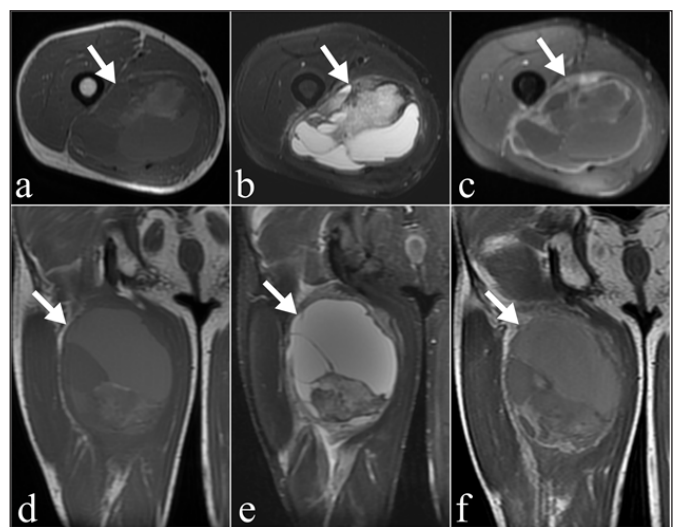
Images show MRI features in a 40-year-old male with FNCLCC grade 3 undifferentiated pleomorphic sarcoma. MRI protocol included, a, axial T1-weighted imaging, b, axial T2-weighted imaging with fat-suppression, c, axial post-contrast T1-weighted imaging, d, e and f, coronal plans of the same sequences, respectively. The tumor is highly heterogeneous in all sequences and has a high T1 signal of hemorrhage. Peritumoral edema and enhancement are present.
